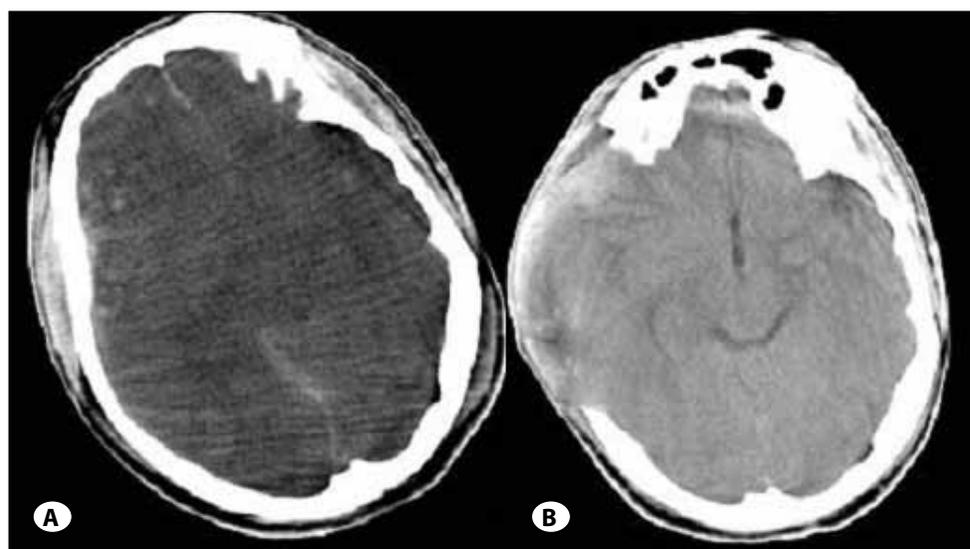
Pre- and postoperative computed tomography (CT) imaging of patient who underwent type I strategy. (A) Preoperative CT scan demonstrating severe contusion in right lateral fissure region and obliterated cisterns. (B) Postoperative CT scan showing significantly decreased brain edema after decompressive craniectomy (DC).
